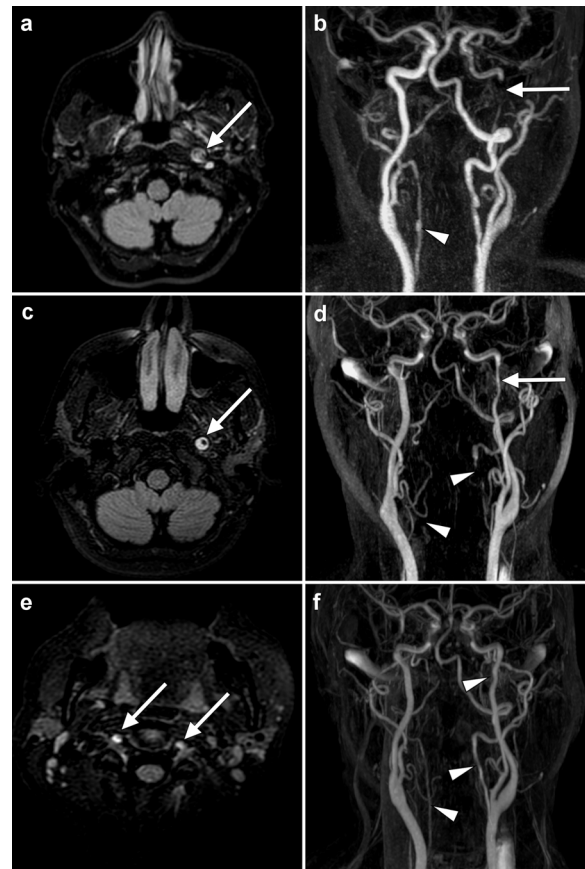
MRI sequences showing the progression of cervical artery dissection in our patient. The initial study (a and b) showed hyperintensity of the intramural thrombus (arrow) in the distal cervical segment of the left internal carotid artery (a: FLAIR sequence) and a filling defect (arrow) compatible with dissection (b: angiography sequence). An irregularity in the right vertebral artery (arrowhead) initially went undetected in this study. One month later (c, d, e) the crescent sign (arrow) persisted in the left internal carotid artery (c: FLAIR sequence), although blood flow had improved (d: angiography sequence). The extracranial segment of both vertebral arteries (e: FLAIR sequence) also showed increased signal intensity (arrows), which was correlated with lack of flow (d: angiography sequence; arrowheads), suggesting bilateral vertebral artery dissection. Angiography sequences obtained 6 months after onset (f) show restoration of blood flow in the left internal carotid artery and both vertebral arteries (arrowheads).
